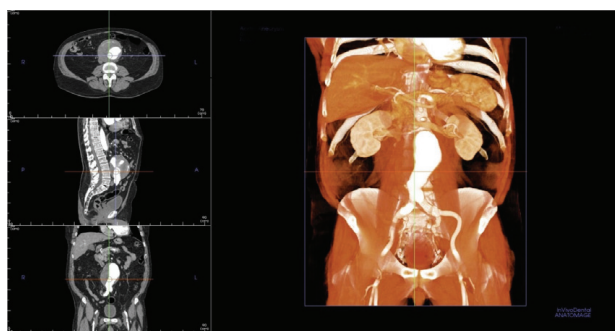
Example of an "egg" created using the Invivo5 Software. The egg was reconstructed from computed tomography DICOM data. It could be displayed on the Anatomage Table or added to the Learning Management System.
